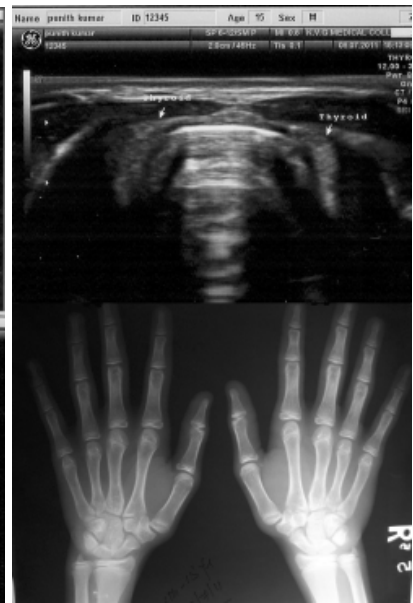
Sonography of the thyroid and xray of the wrists
